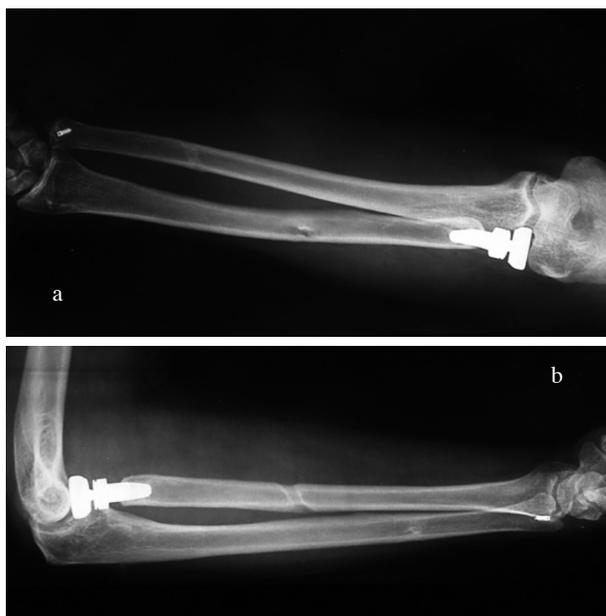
Antero-posterior (a) and lateral (b) radiographic images of the forearm 3.68 years postoperatively
